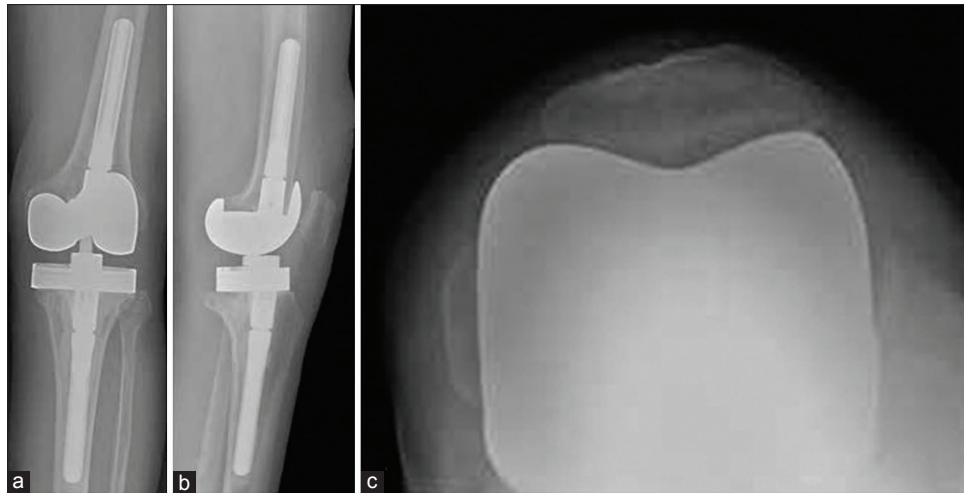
(a) Anteroposterior (b) lateral and (c) Merchant's view of knee joint showing postoperative radiographs after staged revision total knee arthroplasty
